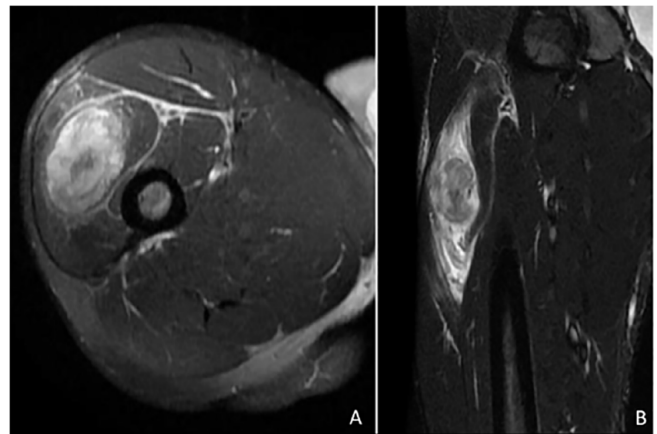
Male patient aged 16 years, without prior history of injury. (A) An axial fat-suppressed MR image shows a predominately hyperintense mass within the vastus lateralis. A target-like configuration is seen created by alternating concentric hypointense rings, presumably representing calcifications and a hypointense centre that may represent fibrosis, blood products or calcifications. (B) A coronal STIR MR image displays a spindle-like inhomogeneous region that follows the orientation of the vastus lateralis, with hyperintense apices, representing muscle oedema and predominately hypointense centre. The differential diagnosis included soft tissue sarcoma.
